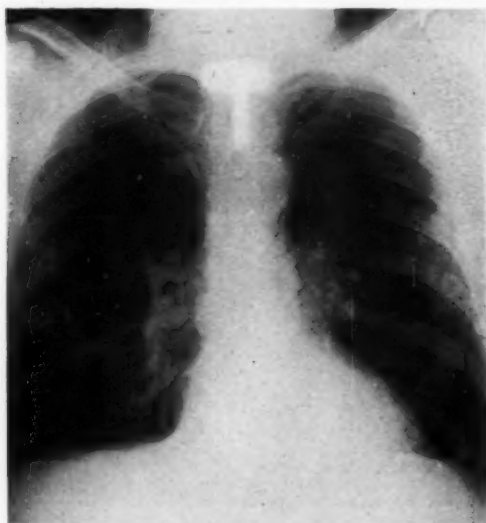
(case 6). Anteroposterior and lateral roentgenograms, revealing stenosis of trachea 20 years after injury.
